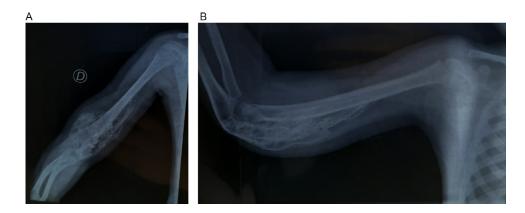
Radiographic images of the right elbow, AP (A) and lateral (B) views, obtained at the last follow-up at 5 years and 11 months of age, showing mild improvement of the myositis ossificans.
